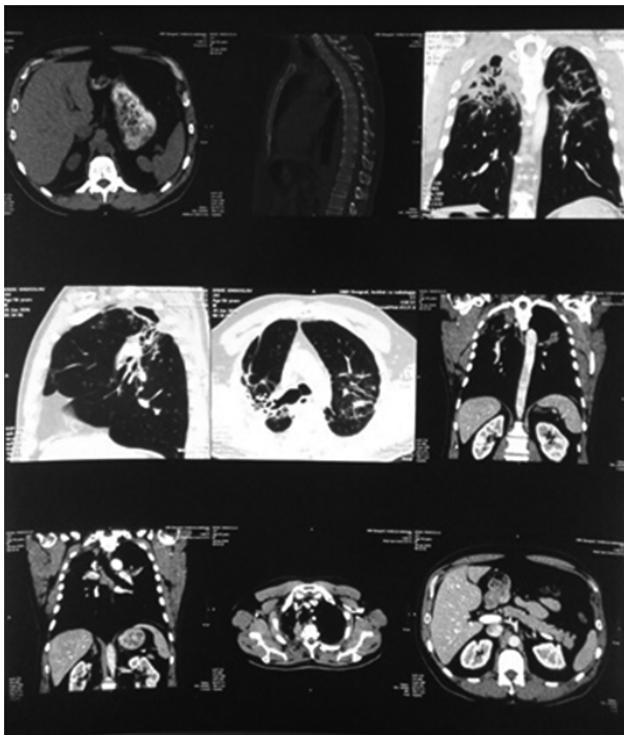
CT scan of thorax and abdomen from 2016. It showed cystic bronchiectasis with fibrosis in the right upper lung which shifted the trachea the into right side. In both lower lobes fibrous changes of lower degree were seen. Mediastinal lymph nodes were enlarged, the biggest was right paratracheal node (26 mm) and infracarinal (20 mm).
